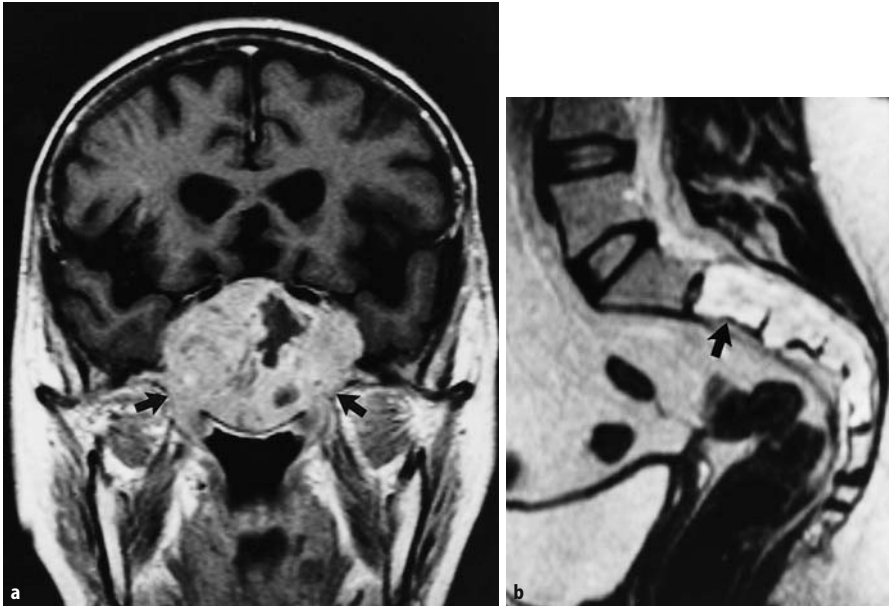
b a Metastasis to the sella region (coronal T1-weighted post-Gd image). RI scan was negative, whereas ^{99m}Tc -sestamibi and ^{18}F -FDG-PET were positive. The tumour shows inhomogeneous contrast enhancement, destroys the surrounding osseous structures, infiltrates the cavernous sinuses and the carotid arteries, and the optic chiasm is no longer identifiable. b Metastases to the sacral bones (except S1; sagittal T2-TSE). RI scan was positive but skeletal scintigram, ^{99m}Tc -sestamibi and ^{18}F -FDG-PET were negative
